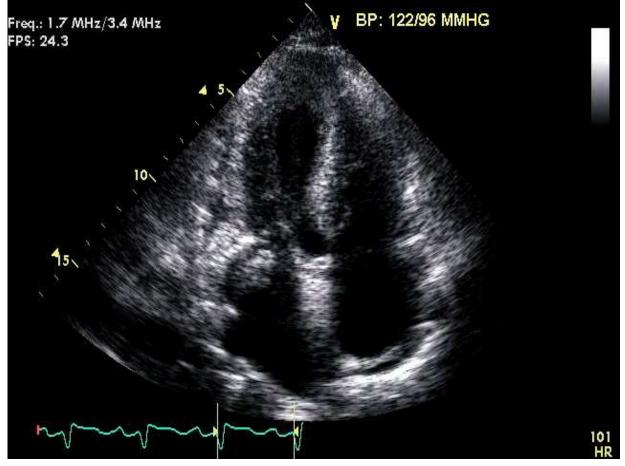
A transthoracic echocardiogram of 4 chambers view showed a large mobile mass (32×17 mm) protruding from the left atrial appendage that was consistent with a thrombus. Concentric left ventricular wall thickening, right ventricular free wall thickening, and the granular "sparkling" appearance of the myocardium was noted
